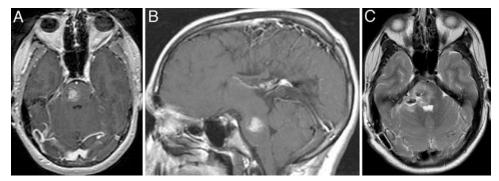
This 12-year-old boy presented with the following symptoms: 2 months of headaches; an episode involving loss of consciousness; dysarthria; paresthesias on the left side of the body and face; and left lower-extremity weakness. Axial (A) and sagittal (B) MR images showed a 1.7-cm CM of the right pons. The patient underwent a right retrosigmoid craniotomy and was discharged 4 days after surgery (C, postoperative axial MR image) with no new deficits, although he did experience some mild left-sided dyscoordination during the first 6 months after surgery. All symptoms had resolved at his 1-year follow-up examination.
